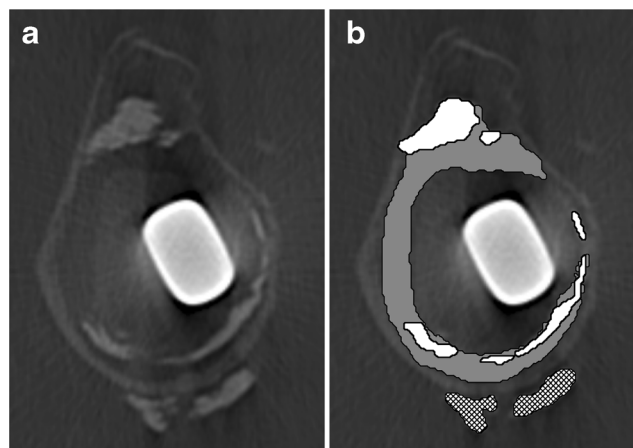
A single axial slice through the CT volume of the same patient as in Fig. 4. In (a) the original image is shown. In (b) the regions of interest are labeled: remainder of interface tissue zone (gray), injected cement at desired location (white), and leaked cement (hatched)
